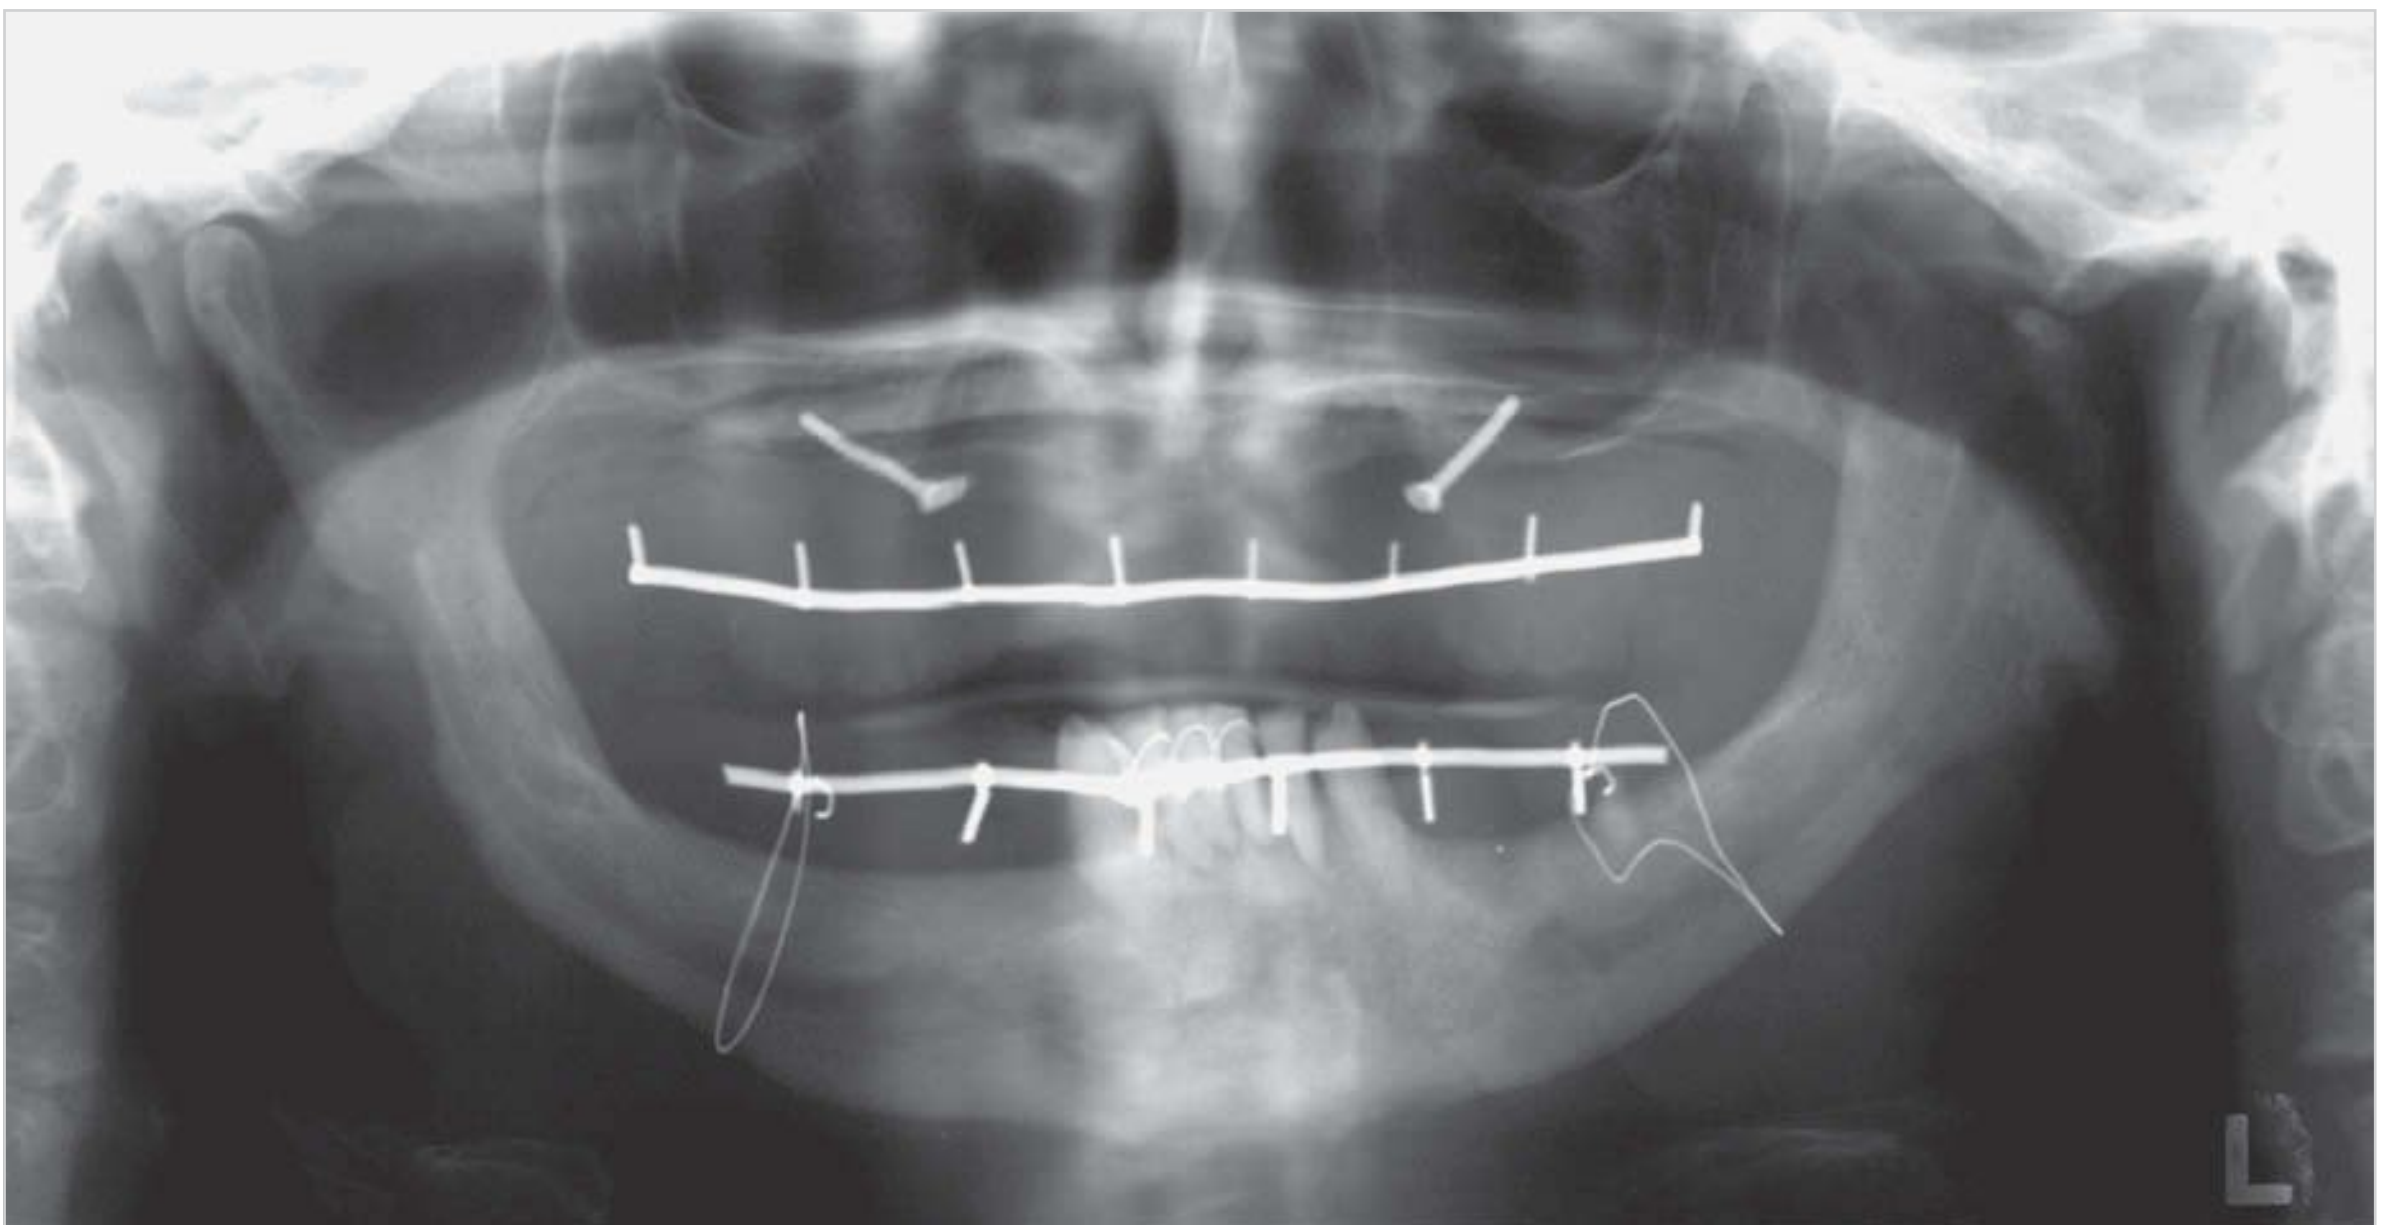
On a later radiograph of the same patient, there was much less anterior widening.
